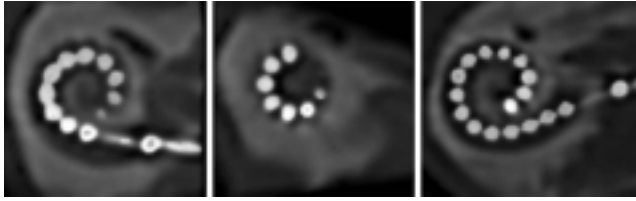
A. Multi-slice CT (MSCT) of the basal part of the first temporal bone, showing good modiolar proximity. B MSCT of the apical portion of the first temporal bone, showing 530° insertion depth and a lateral position of the apical half of the array. C. MSCT of the second temporal bone, showing the position of all individual electrode contacts.
